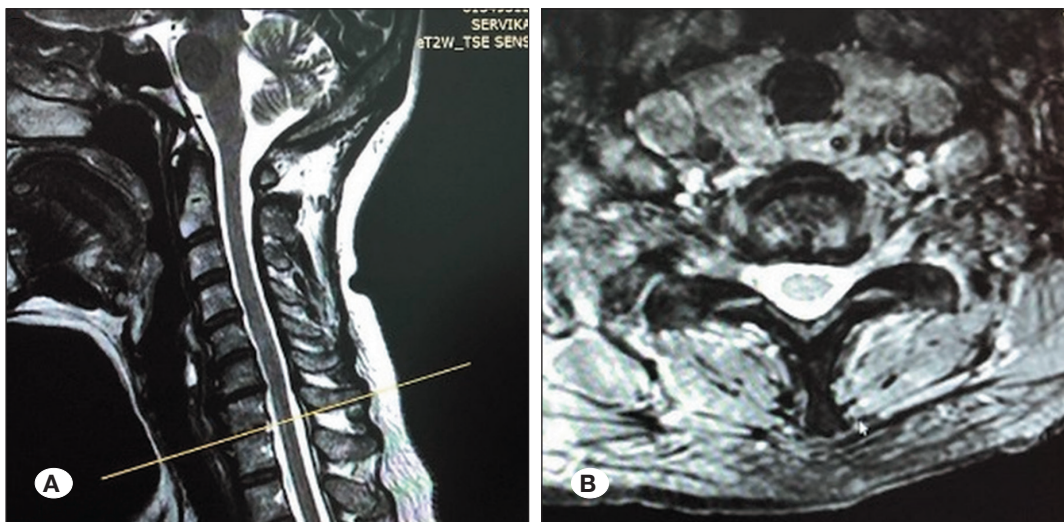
Sagittal (A) and axial (B) magnetic resonance imaging scans taken at postoperative 24 months, showing healing without fusion and good alignment.
